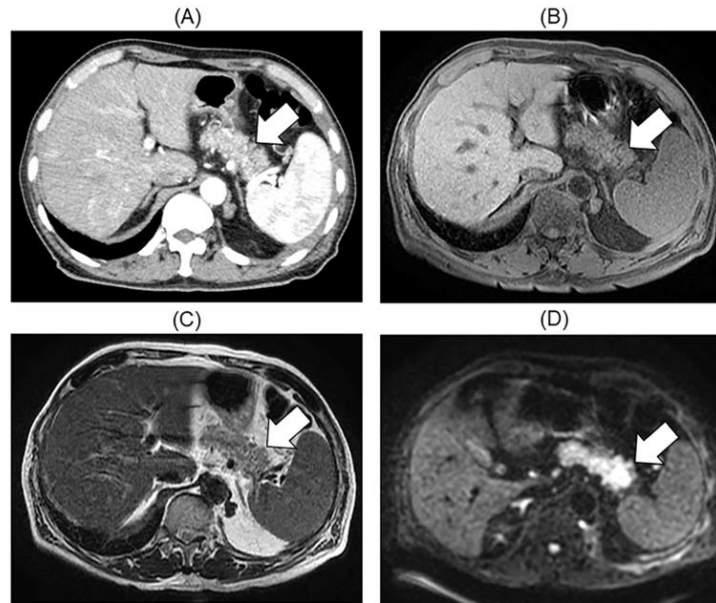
Contrast-enhanced computed tomography imaging revealed hypoenhancement in the pancreas in the early phase of the contrast (A), and magnetic resonance imaging revealed low signal in fat-suppressed T1 weighted image (B), modest increased signal in T2 weighted image (C), and high intensity in diffusion weighted image (D).
